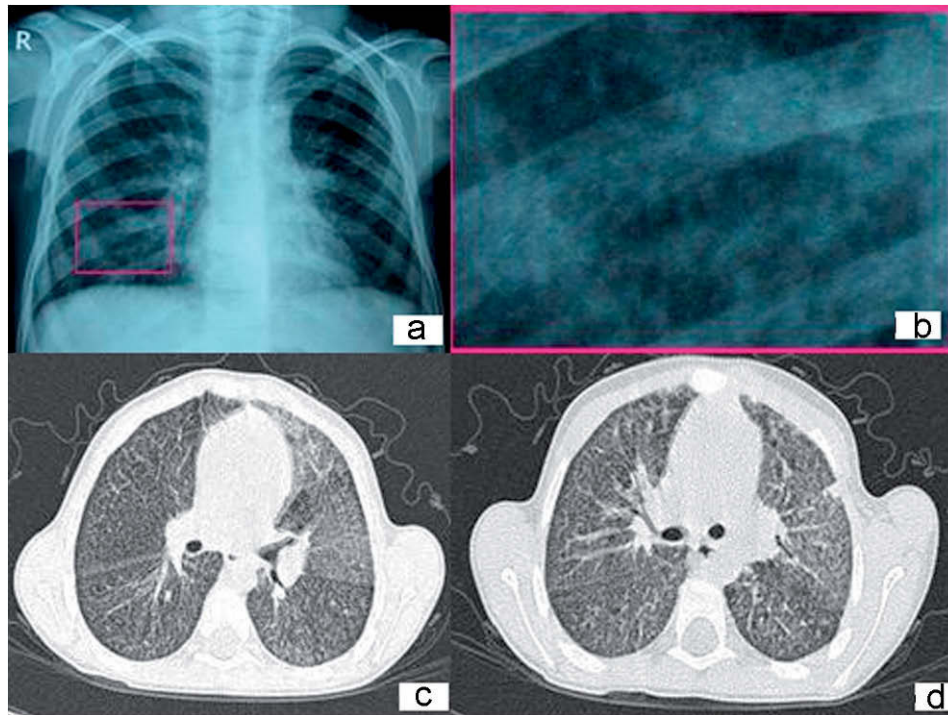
a) The postero-anterior radiography shows diffuse reticulonodular infiltrate in the base of both lungs. b) Close-up of reticulonodular infiltrate affecting the lower parts of the lung. c) High-resolution computed tomography (HRCT) showing a ground-glass section accompanied by septal interlobular-intralobular thickening and peribronchovascular interstitial thickening. d) HRCT of the superior areas of the lung showing subpleural nodules.
